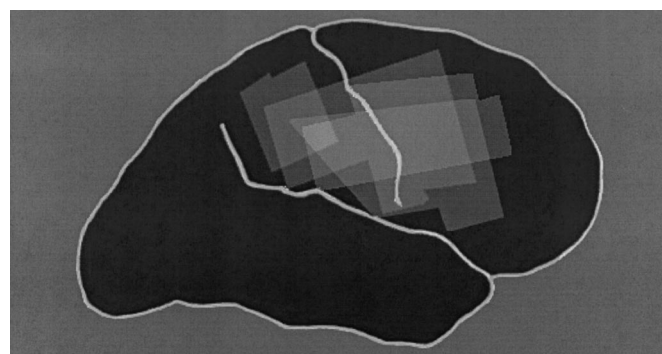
A depiction of the sites of the cortical lesions identified from CT scans for five (of six) of the patients (the lesion of the patient with subcortical damage is not represented).
